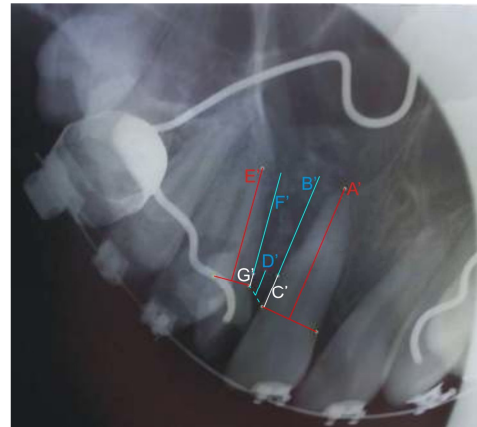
Linear measurements recorded on Post operative Occlusal radiographs using CorelDraw suite 15.
